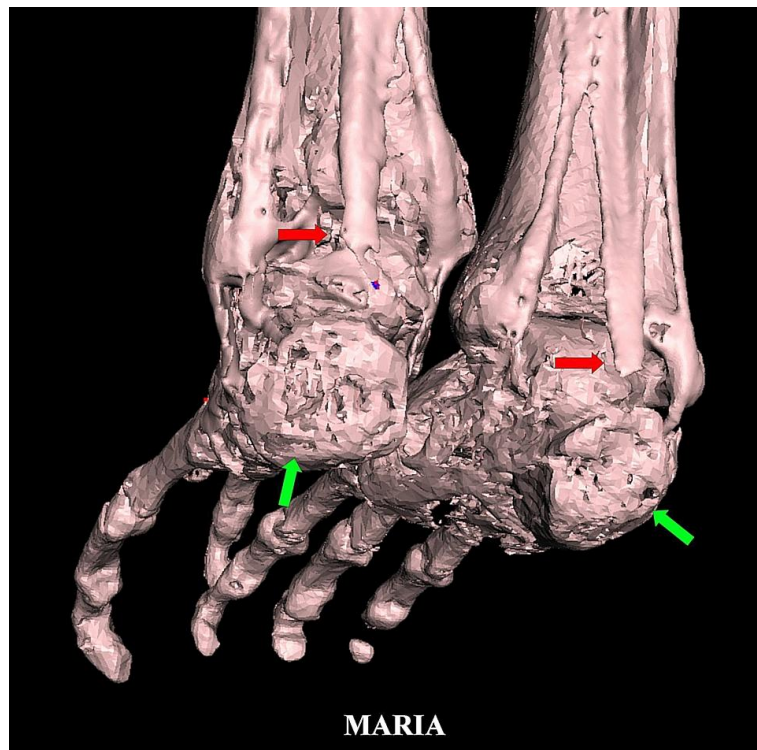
3D CT showing bilateral heels. Posterior parts of both calcanei were found truncated (*green arrows*). The lower part of Achilles tendons were also cropped (*red arrows*), more in left heel.
